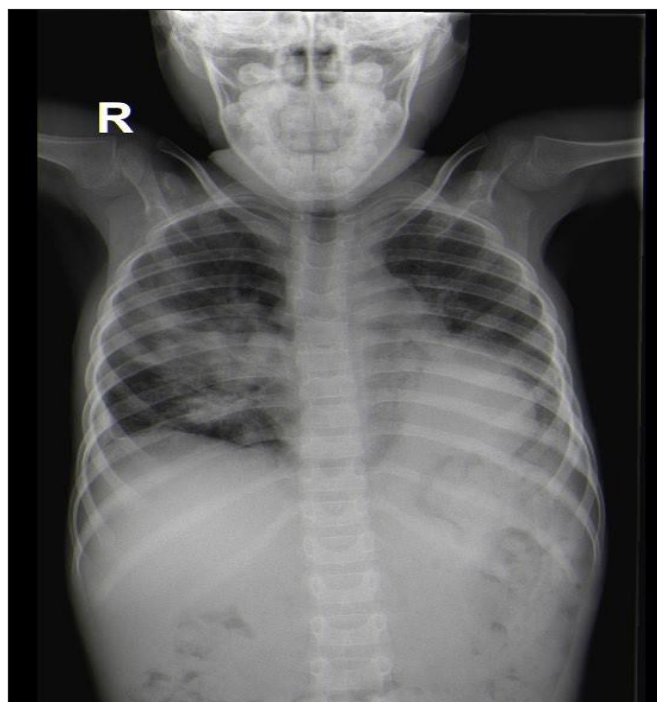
Chest radiograph (anteroposterior view) showing splayed carina, infiltrates in the right middle lobe, and a confluent opacification in the lingular region.
